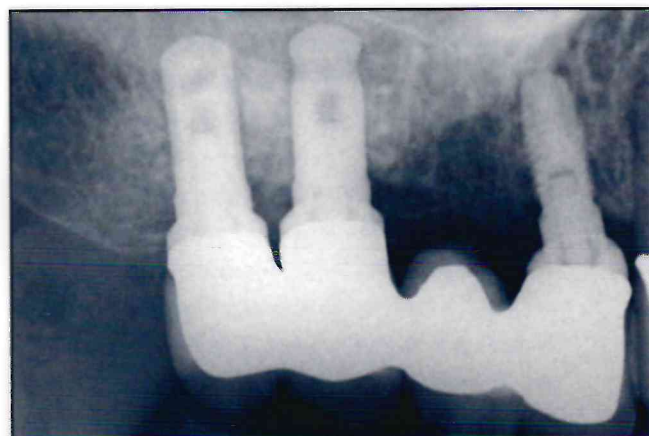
Radiographic view of the definitive Artglass-fused-to-gold restoration 5 years following implant placement.
